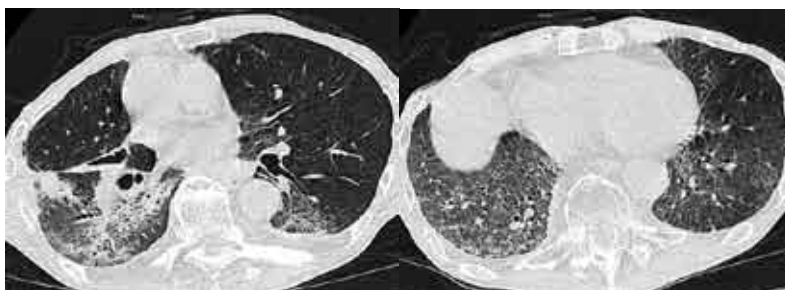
Chest computed tomography (CT) scans obtained before (A) and 6 months after initiation of treatment with gefitinib (B).
